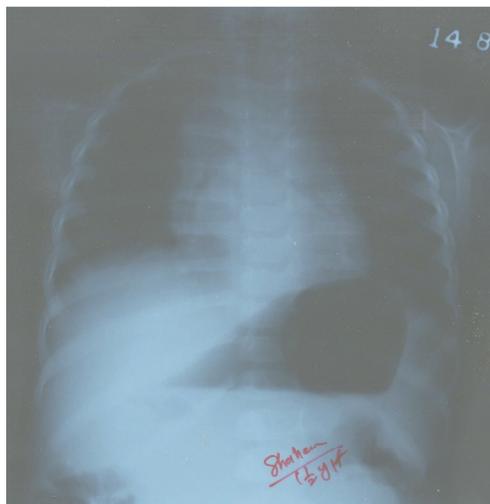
X-Ray chest PA view shows a homogenous soft tissue density shadow in the superior mediastinum
